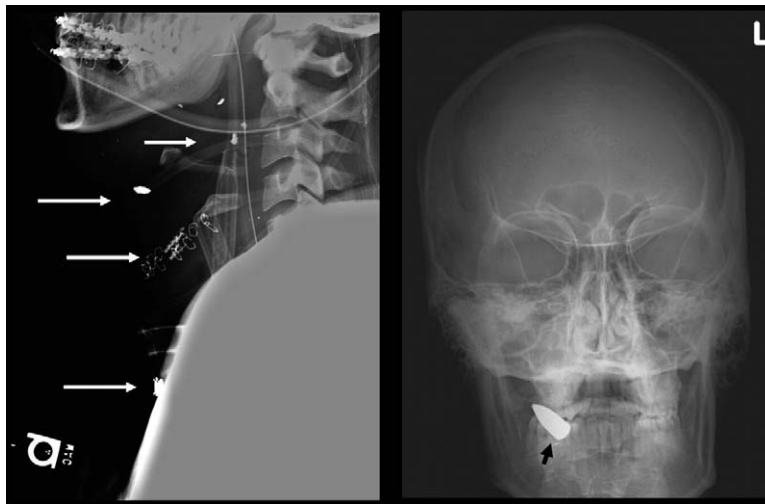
Plain radiographs demonstrate that metallic deposits by explosive munitions (*long white arrows*) or high velocity weapons (*short black arrow*) can predict the potential inaccuracy of a computed tomography angiography.
